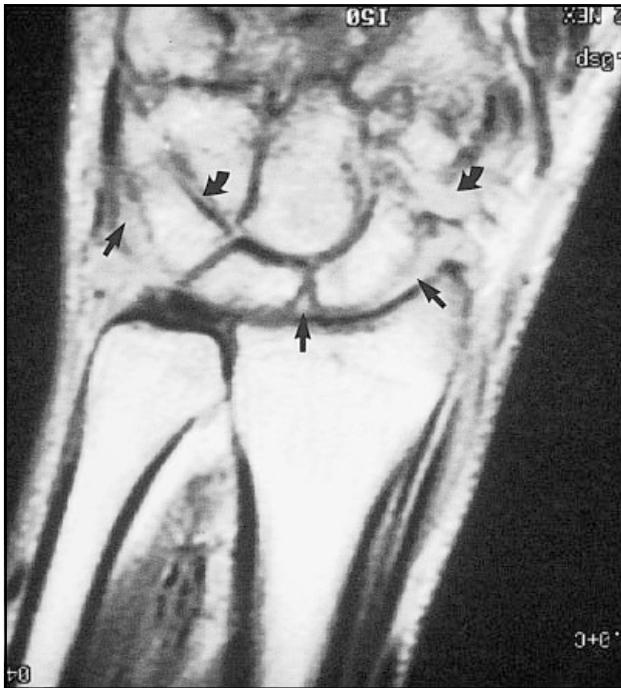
Postcontrast-enhanced coronal T1-weighted image of the wrist (TR 400 ms/TE 19 ms). All joint spaces are filled with enhancing material (arrows), with no discernible fluid remaining.
